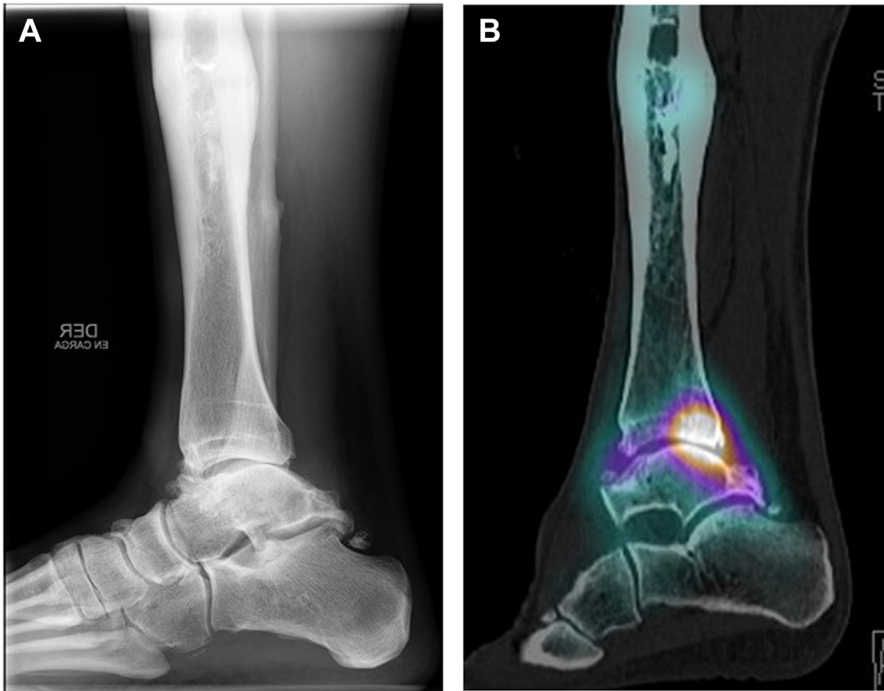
Lateral radiographs of 2 clinical cases with ankle sagittal malalignment. (A) A case with anterior ankle arthritis, with anterior displacement of the talus relative to the tibia and anterior ankle arthrosis with a concurrent decrease of the ADTA angle. (B) A case with posterior ankle arthritis, with posterior displacement of the talus relative to the tibia, with an increase of the ADTA angle.
